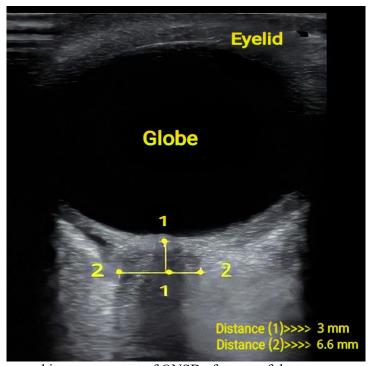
Sonographic measurement of ONSD of a case of the severe preeclampsia group.
